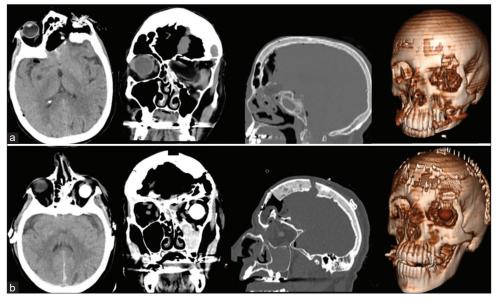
Preoperative (a) and postoperative (b) axial, coronal, and sagittal computed tomography images of the repair site. The far-right images represent 3D reconstructions of the skull trauma and subsequent repair.
